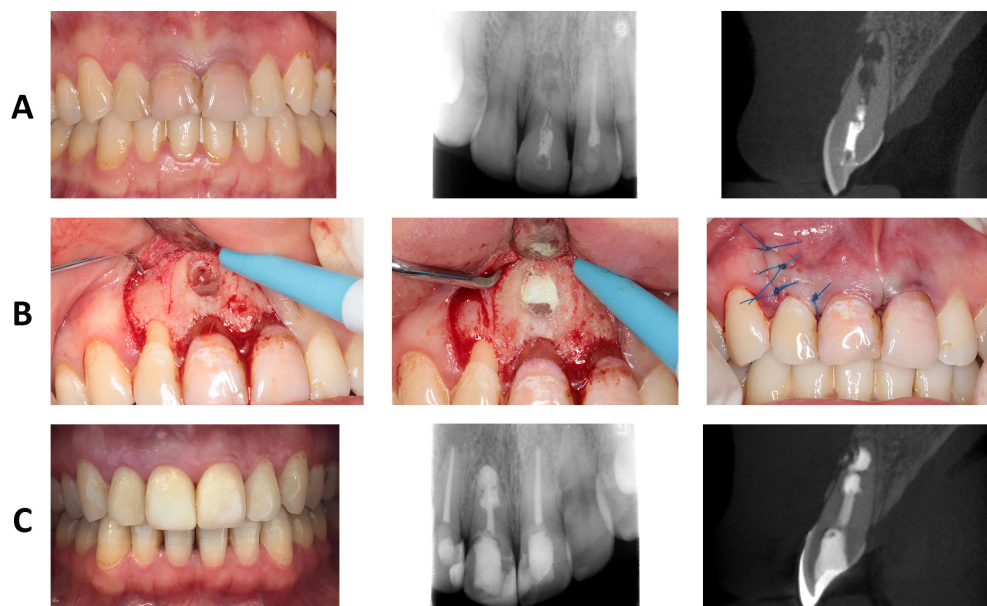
A) Preoperative intraoral image, periapical radiography, and CBCT image of the tooth presented from left to right; B) intraoperative area after flap elevation, sealing of resorption area with MTA, and postoperative intraoral image presented from left to right; C) intraoral image, periapical radiography, and CBCT image of the tooth after one-year follow-up presented from left to right.
